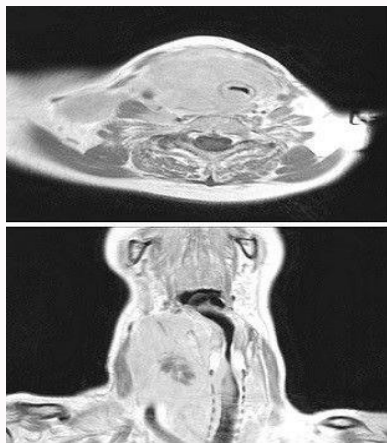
MRI that shows severe compression and distortion of the upper trachea.
